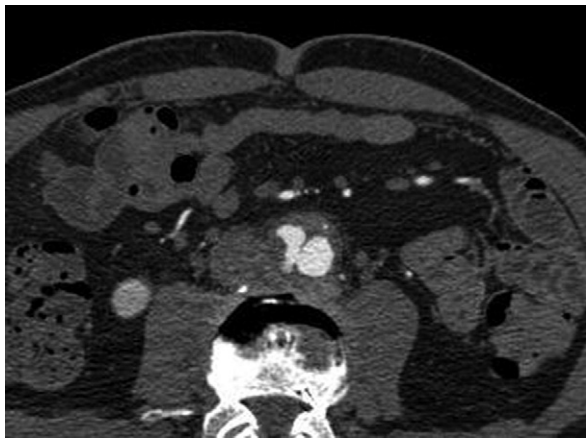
Repeated abdominal computed tomographic scan 2 weeks after the initial study, revealing worsening of the periaortic inflammation. The aorta now measured 3 cm in maximum diameter. This prompted surgical consultation and, eventually, surgical intervention.
